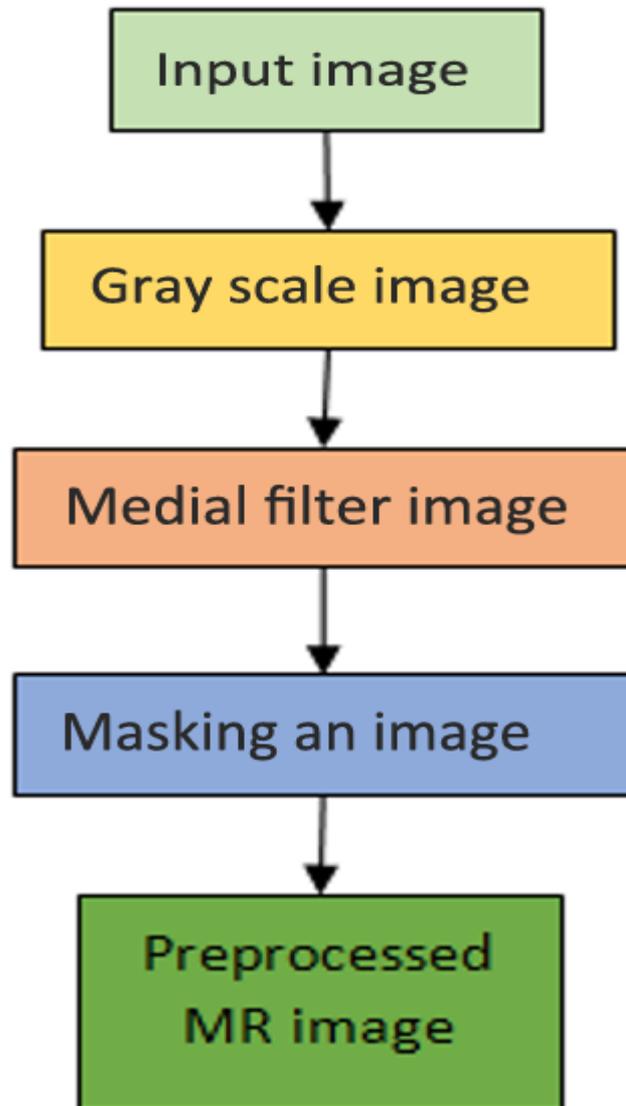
Preprocessing steps for the MR image.
